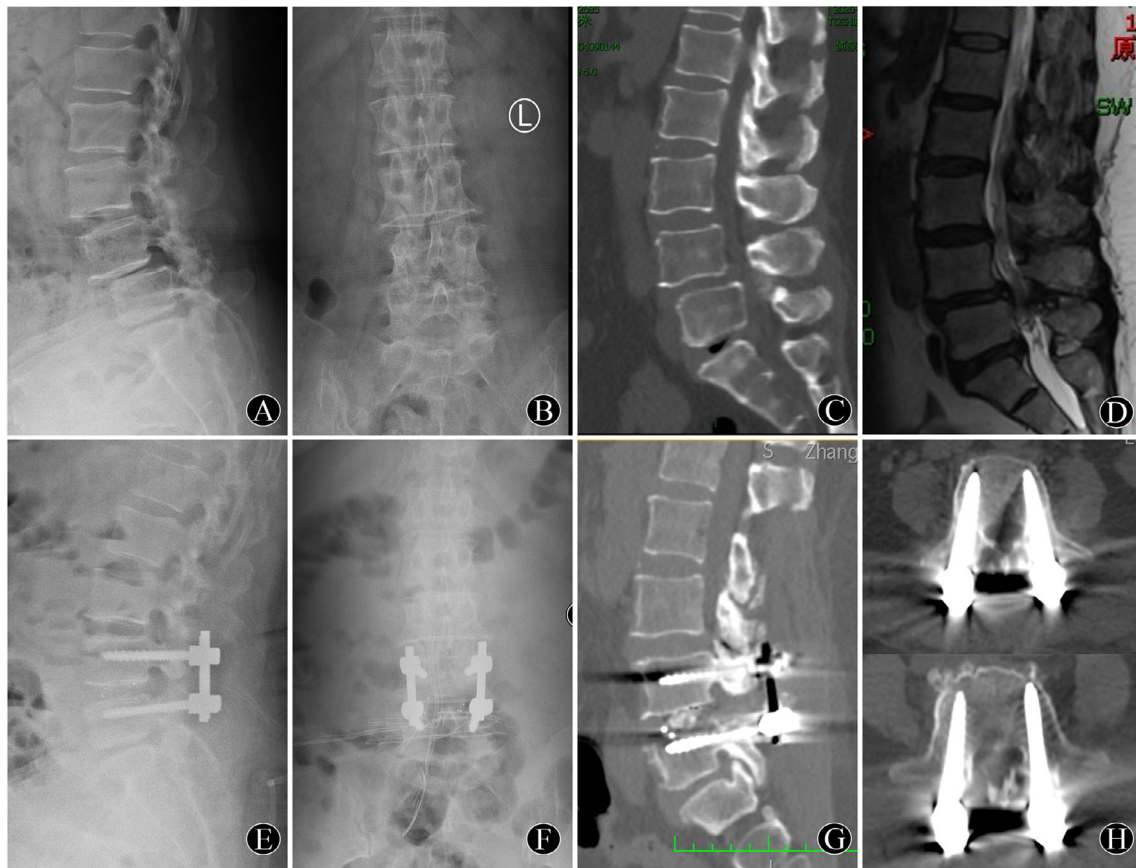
A 53-year-old woman with lumbar degenerative spondylolisthesis ($L_{4/5}$) underwent robot-assisted Mis-TLIF surgery. (A, B) Preoperative X-ray films showing lumbar degenerative spondylolisthesis ($L_{4/5}$). (C) Preoperative CT image showing lumbar degenerative spondylolisthesis. (D) Preoperative T2WI sagittal MR image showing spondylolisthesis and spinal canal stenosis. (E, F) One-week postoperative X-ray films showing excellent vertebral reduction and pedicle screw position. (G) One-year postoperative CT image showing interbody fusion has been achieved. (H) One-year postoperative CT transverse images showing the precise position of the pedicle screws.
